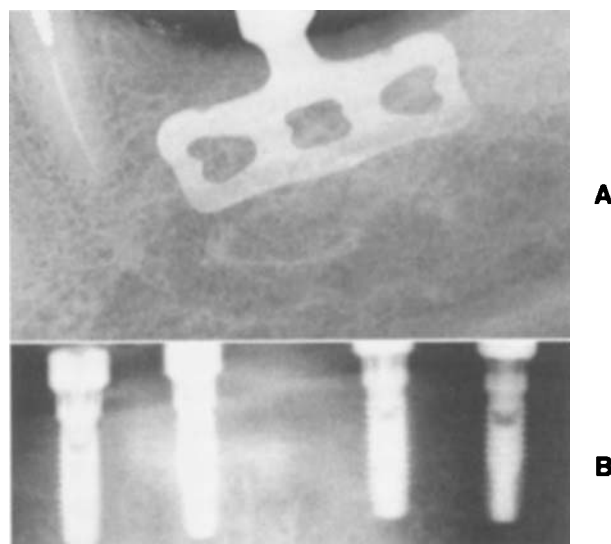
■ Postinsertion radiographic check of plate/blade form (A) and root forms (B).
